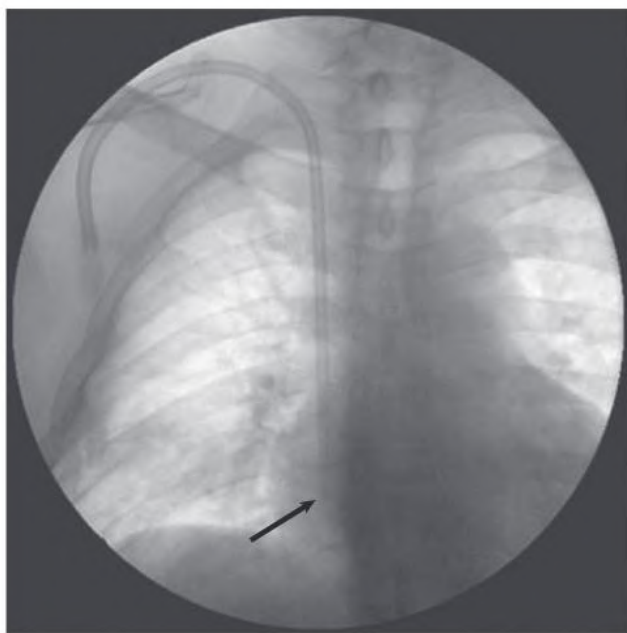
Insertion of a Venous Catheter for Hemodialysis. Chest radiograph confirming that the tip of the catheter (arrow) is at the junction of the superior vena cava and the right atrium.
